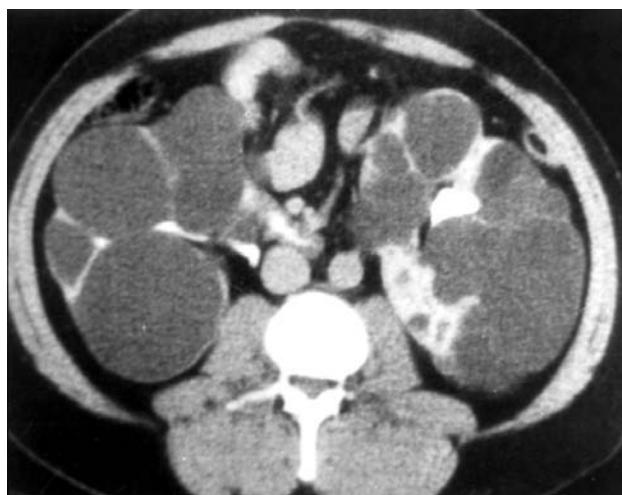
CT scan kidney's showing bilateral multiple cysts indicating polycystic kidney disease
